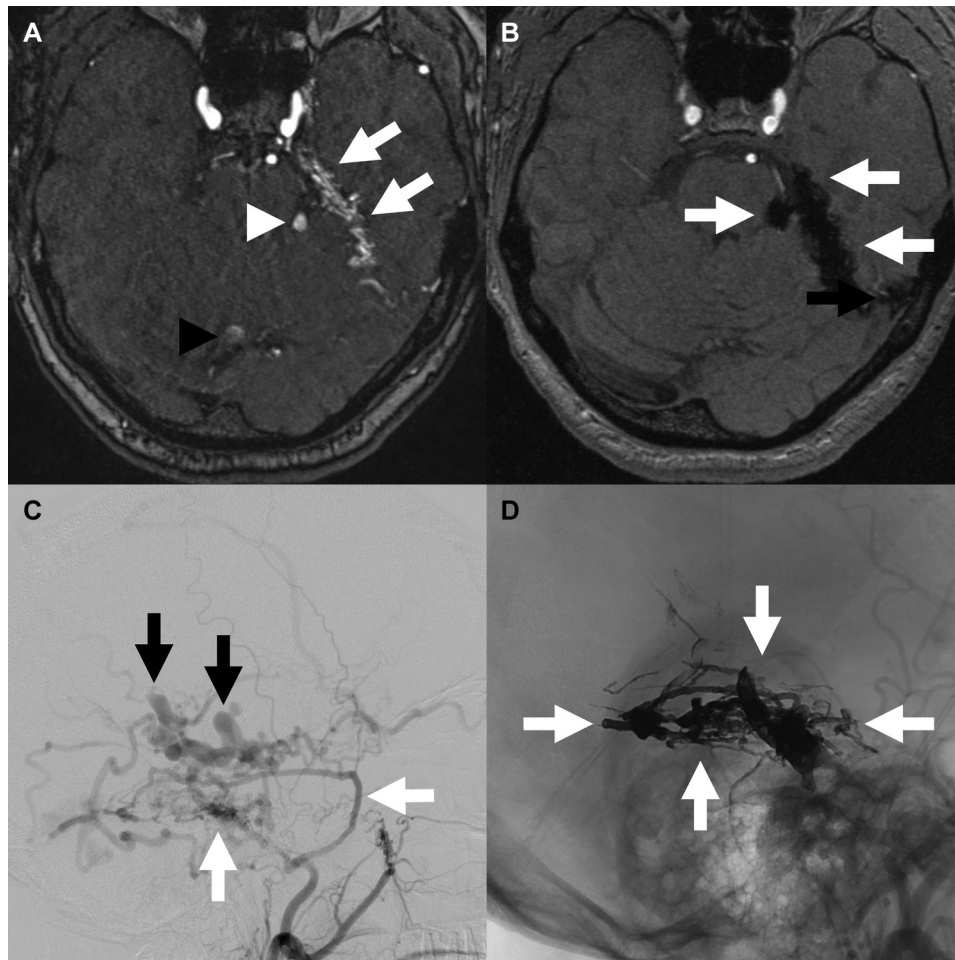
Example of a DAVF. Pre- (A, C) and post-interventional (B, D) images of a patient with a symptomatic (pulsatile tinnitus) DAVF of the tentorium. MRI TOF angiography shows multiple hyperintense tubular structures around the left-sided tentorium, (arrows in A) and arterialized blood flow within adjacent dilated cortical veins (white arrowhead in A) and within the straight sinus (black arrowhead in A). In the pre-interventional DSA, multiple feeding arteries from the middle meningeal artery (white arrows in C) shunt into dilated cortical veins (black arrows in C), corresponding to a Cognard IV/Borden type III DAVF. After endovascular liquid embolization (radiopaque embolic agent: white arrows in D), the DAVF is completely occluded and the pulsatile tinnitus is no longer present. In post-interventional MRI (B), the embolic agent is visible as hypointense material (arrows in B). Pathological arterialized blood flow is now longer visible. DAVF: dural arteriovenous fistula; MRI: magnetic resonance imaging; TOF: time-of-flight
